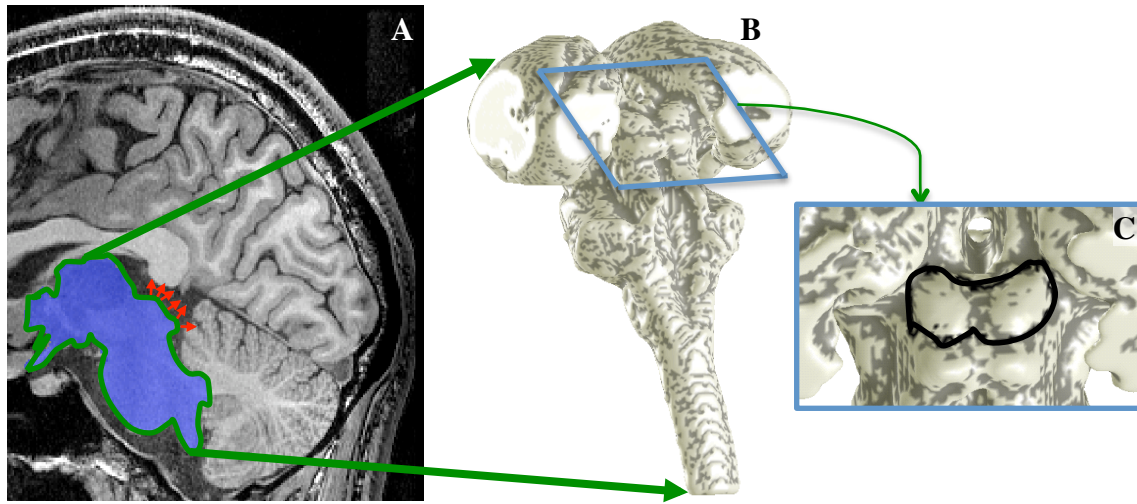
Segmentation and surface modeling. A) Portions of thalamus and brainstem including midbrain segmented from high-resolution MRI reference anatomy. B) 3D surface created at the edge of segmented region and smoothed. C) Rotated and enlarged view of the midbrain to visualize data on the SC (outlined in black)
